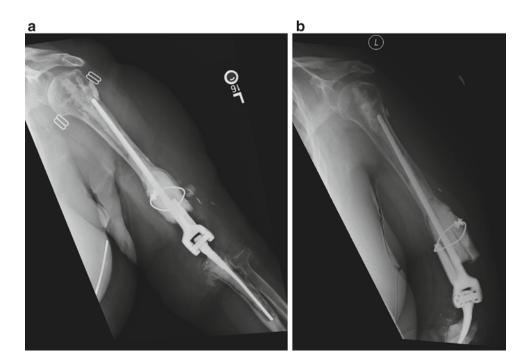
Presentation plain film images (a, b) showing long stem cement total elbow arthroplasty
